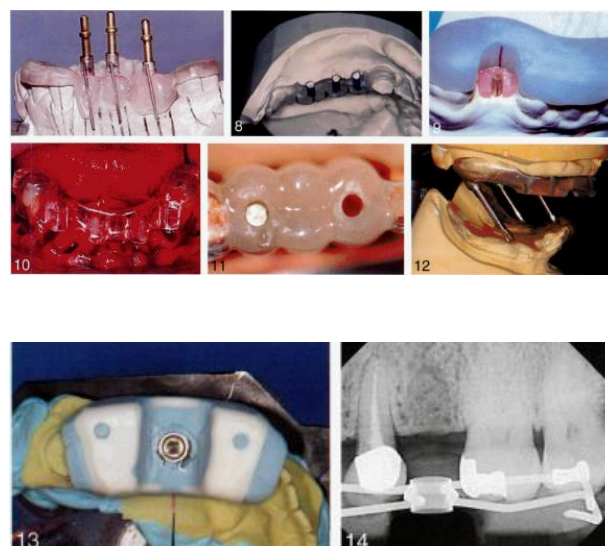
FIGURE 7. Guide pins attached to the surgical guide to verify alignment of implants. FIGURE 8. Facial portion of surgical template removed before surgery.. FIGURE 9. Two-piece implant placement surgical guide. FIGURE 10. Surgical guide for immediate implant placement following staged tooth extraction. FIGURE 11. Radiographic rod removed following radiographic analysis. FIGURE 12. Surgical guide connected to mandibular record base. FIGURE 13. Cast-based surgical guide. FIGURE 14. Radiographic view of the cast-based surgical guide.
